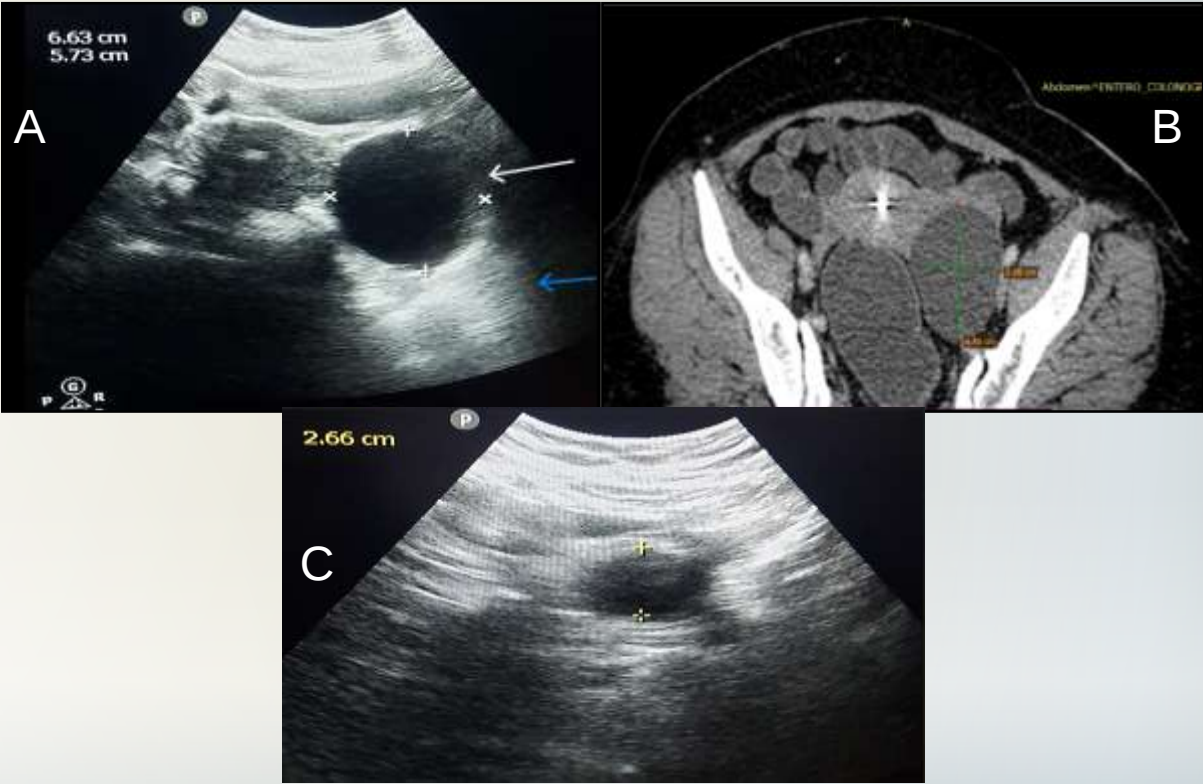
A 47 years old female with history of chronic abdominal pain for 5 years. Referred for US assessment of an incidentally detected left adnexal lesion on CT enterocolonography. A) Transabdominal grayscale US transverse view showing a left simple ovarian cyst measuring 6.63 cm in maximum dimension. B) CT enterocolonography performed 1 day prior showing the same left simple ovarian cyst. The cyst showed complete resolution at three month follow up as shown in (C).
